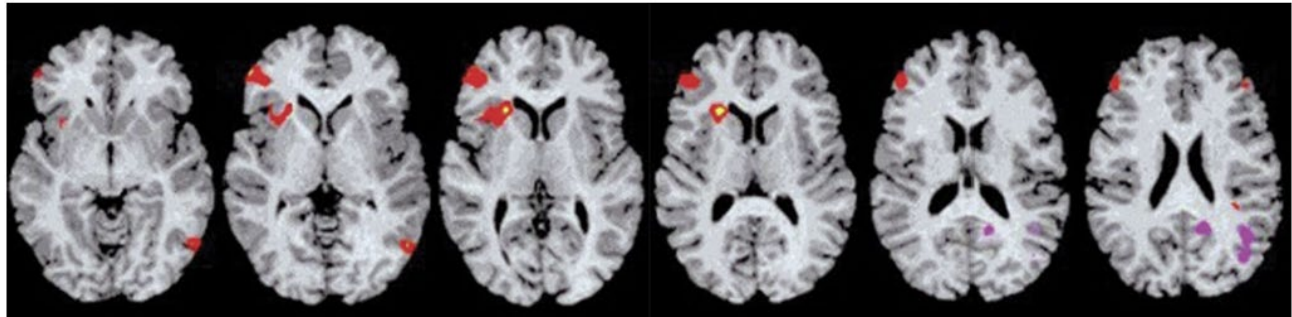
³³. Functional-MRI readings of PTB brain: Damaged/underdeveloped regions shown in red
